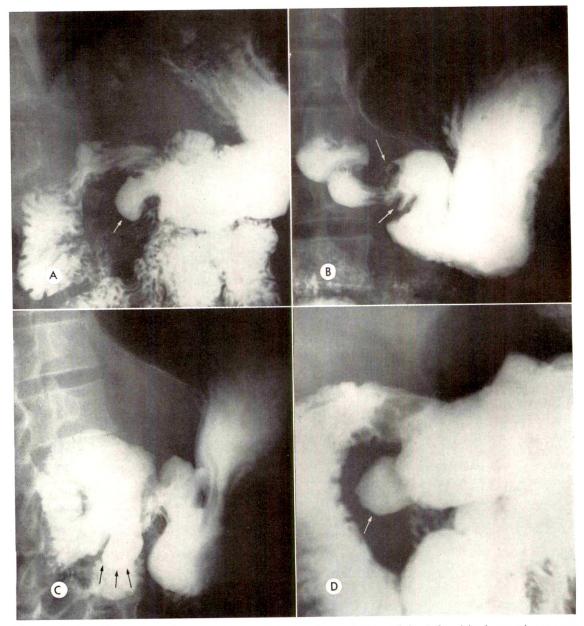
Roentgenograms of 4 different patients demonstrating variations of the deformities in gastric contour that have been encountered. These patients were all asymptomatic at the time of examination. (A) A well-defined, pouch-like deformity which was visualized on all roentgenograms of this patient's upper gastro-intestinal series. (B) Marked deformity of the gastric antrum which was pliable at fluoroscopy and has remained unchanged on follow-up examinations. The patient has remained asymptomatic. (C) Marked deformity in a completely asymptomatic patient. There is irregularity of the stomach contour and an associated inferior protrusion. (D) A characteristic pouch-like protrusion along the inferior border of the gastric antrum. Note the similarity to A.
